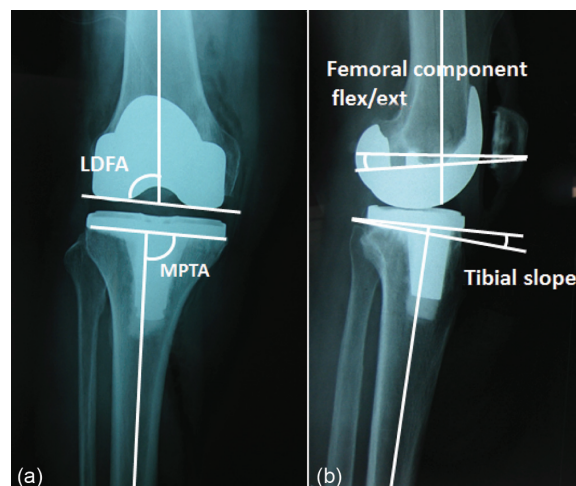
(a) LDFA and MPTA were measured from the 3 feet AP weight bearing radiograph while (b) femoral component flexion and tibial posterior slope were measured from the lateral radiograph.
